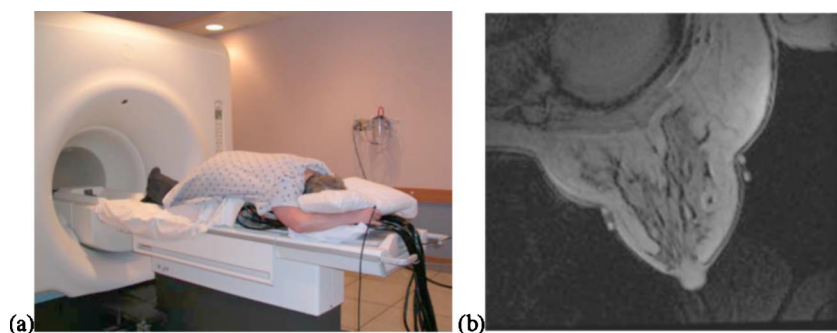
(Color online) Photograph in (a) shows a female volunteer prepared for the simultaneous MRI-NIR exam. In an anatomical axial T1-weighted MRI slice from the right breast, (b), fiducial markers (outside the breast) indicate the location of the fiber plane.
